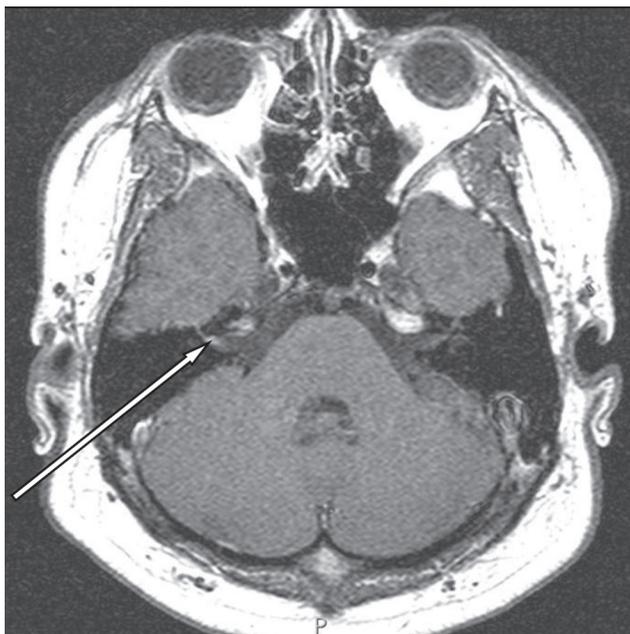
Magnetic resonance imaging scan shows focal enhancement in the distal portion of the right internal auditory canal without other abnormality.
